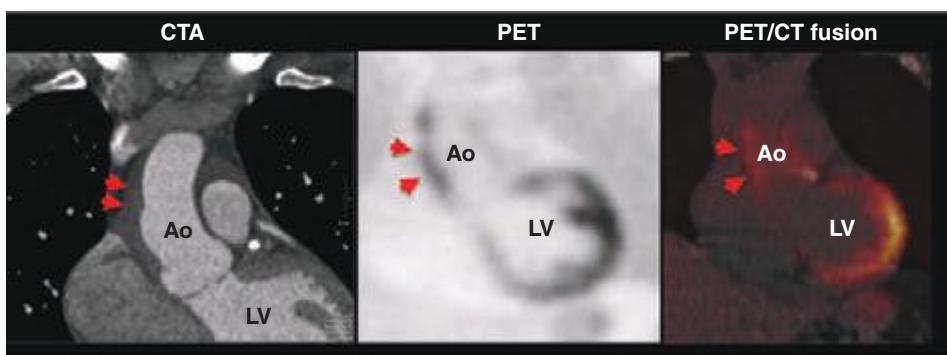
37 Representative coronal computed tomography (CT) angiographic (CTA; *left panel*), fluorodeoxyglucose (FDG) positron emission tomography (PET; *middle panel*), and fused CT and PET (*right panel*) images in a patient with suspected aortitis. The CTA images demonstrate thickening of the ascending aorta (Ao), which correlates with intense, focal FDG uptake consistent with active inflammation. LV, left ventricle.
